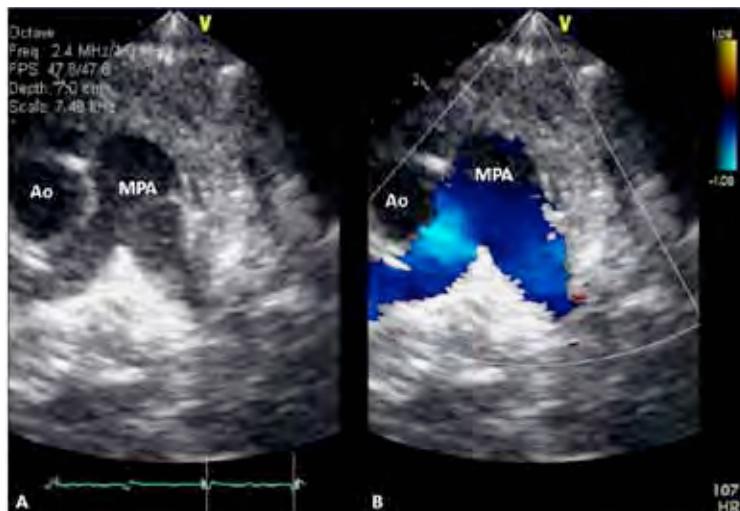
Selected video frames from precordial short axis views of an echocardiogram performed on the day following ductal closure demonstrating no residual shunt. AO, aorta; MPA, main pulmonary artery.
